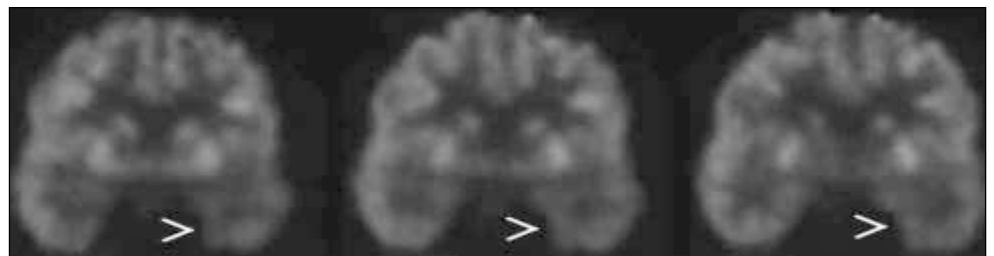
There is decreased interictal FDG uptake within the left temporal lobe of this patient with medically refractory epilepsy (arrows). No other foci of abnormal cortical activity were localized. The patient subsequently underwent successful left temporal lobectomy for treatment.
